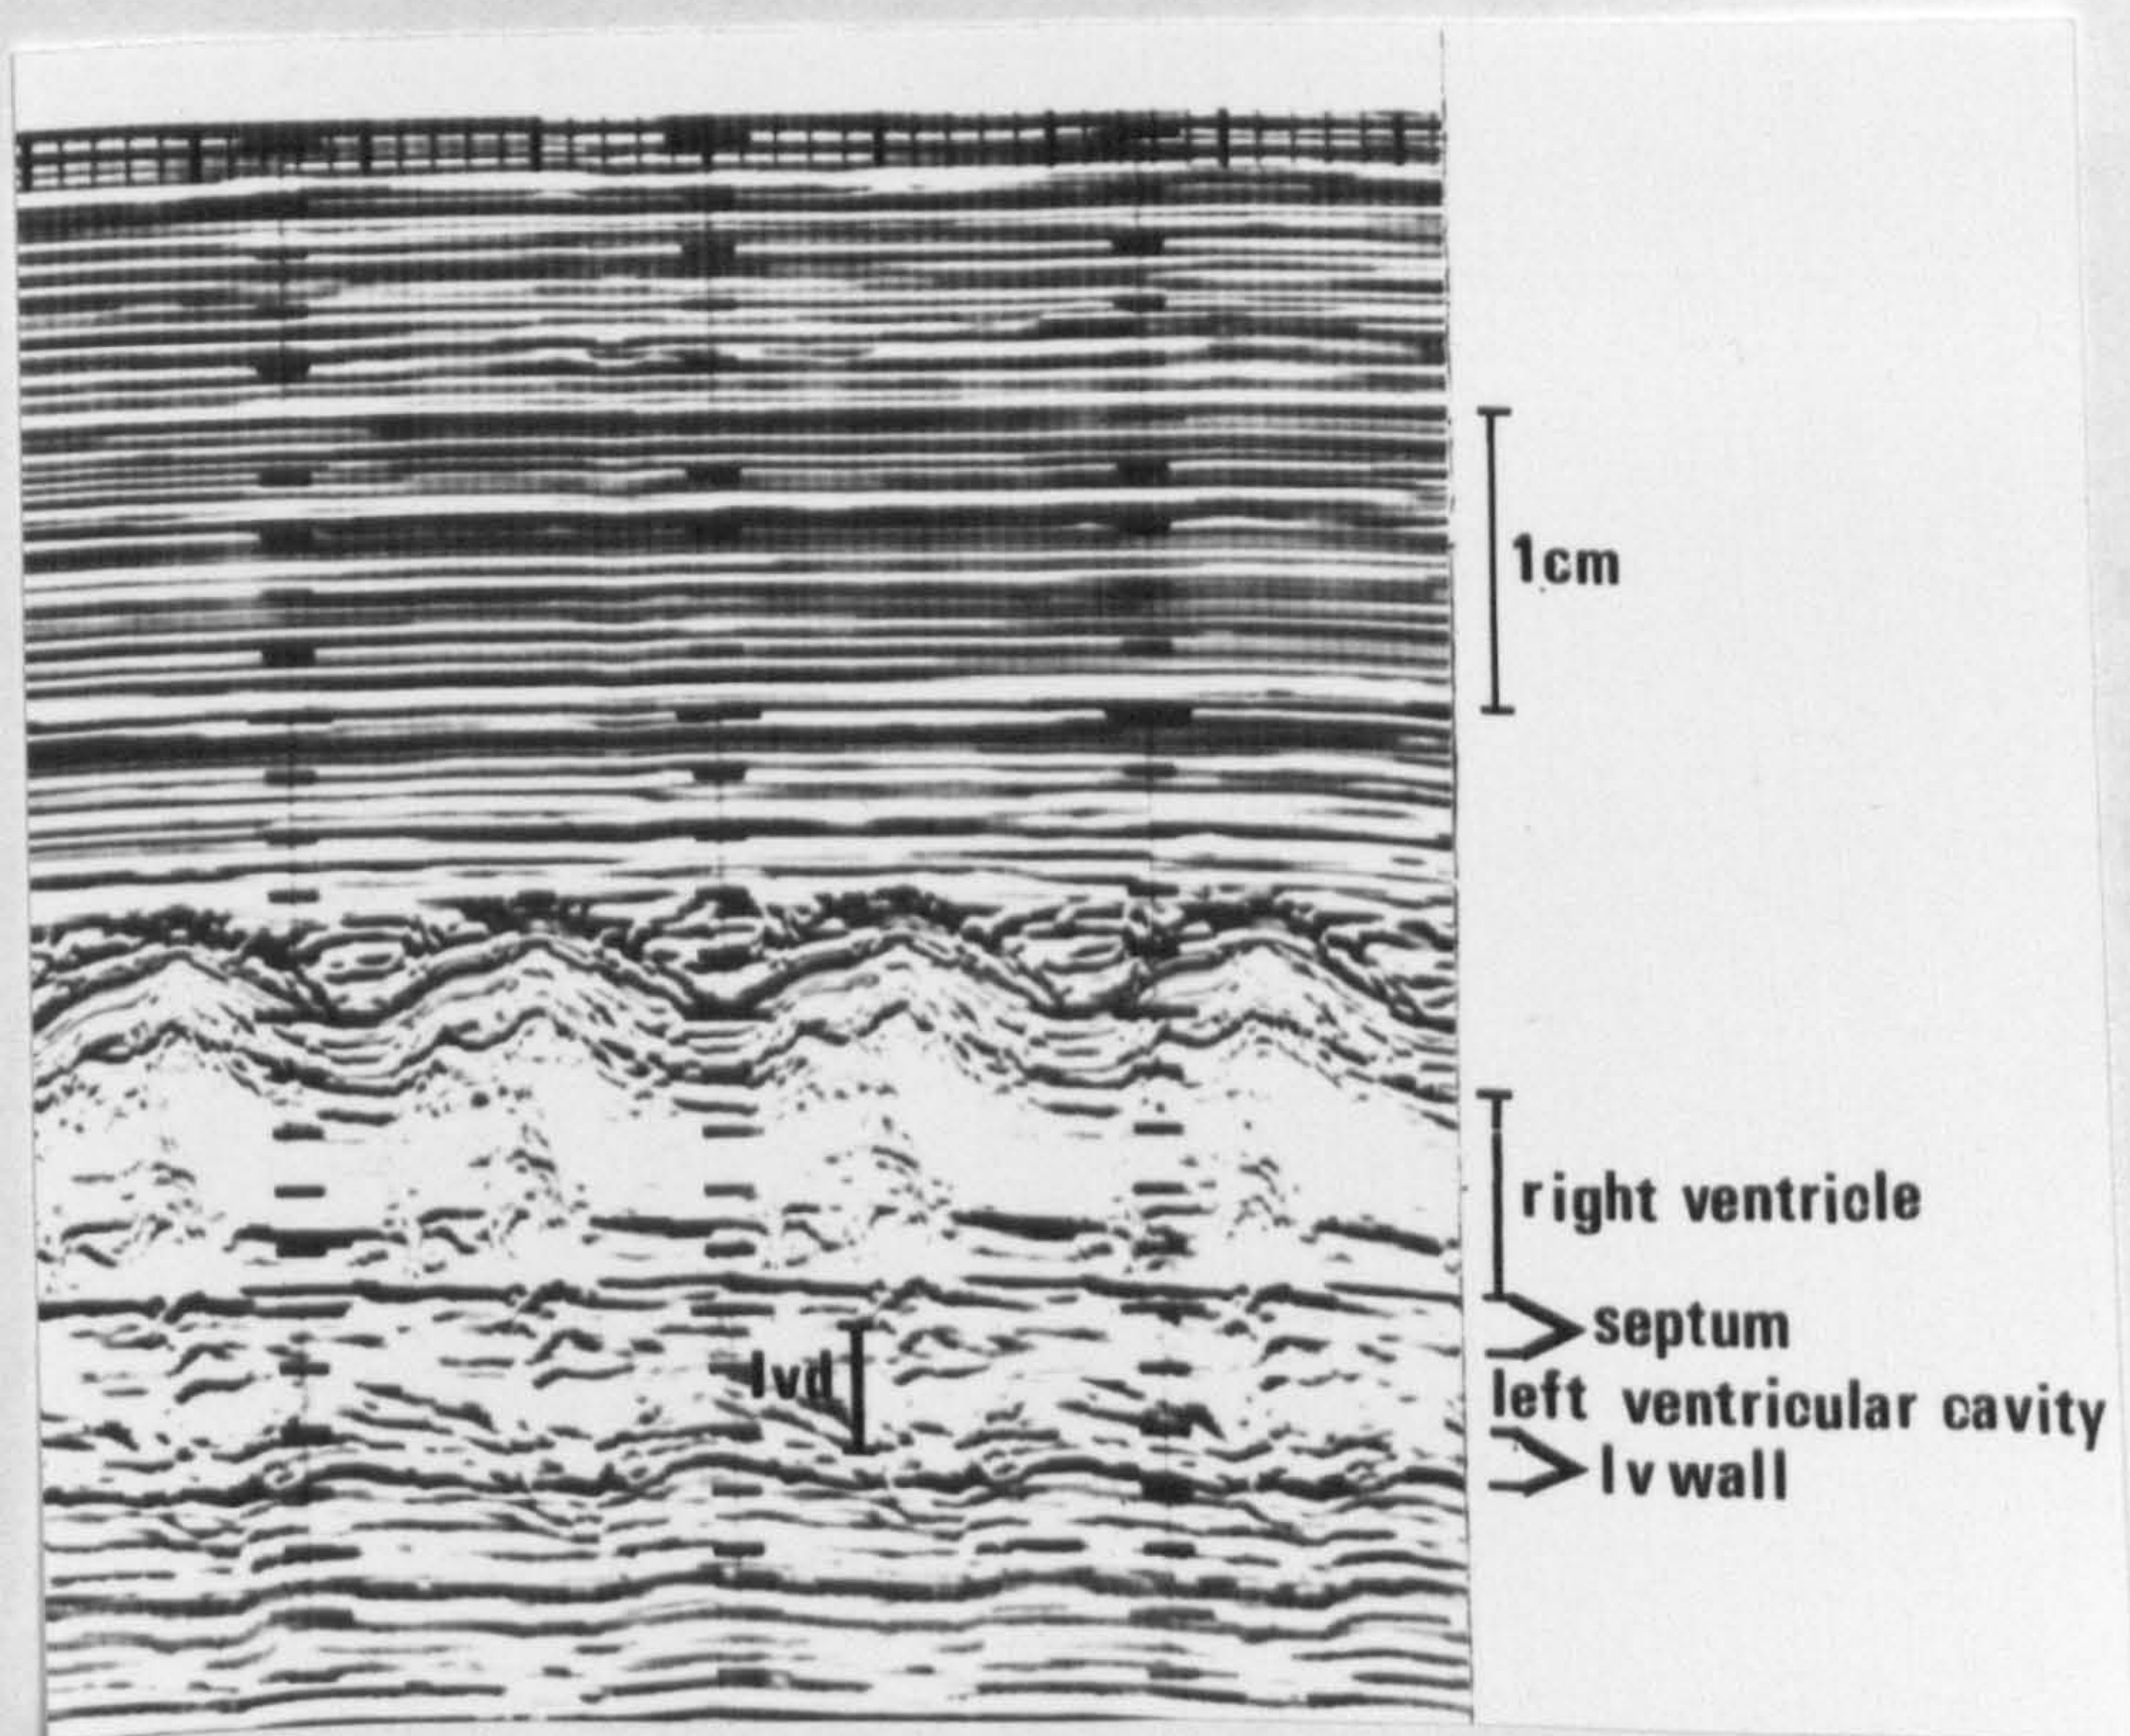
The M mode echocardiogram demonstrates a large anterior ventricle with a small posterior cavity. No atrioventricular valve could be found entering this chamber.
